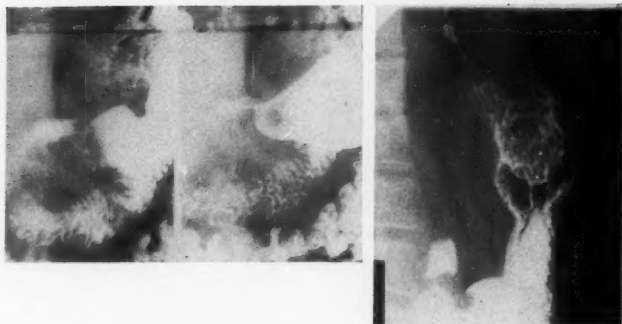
Characteristic roentgenograms of gastric leiomyomata
